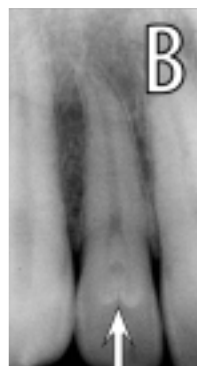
Talon cusp; 7B: Dens invaginatus; 7C: Clinical appearance of dens invaginatus; 7D: Radiographic detail of dens evaginatus - note how the pulp extends into the central tubercle.
